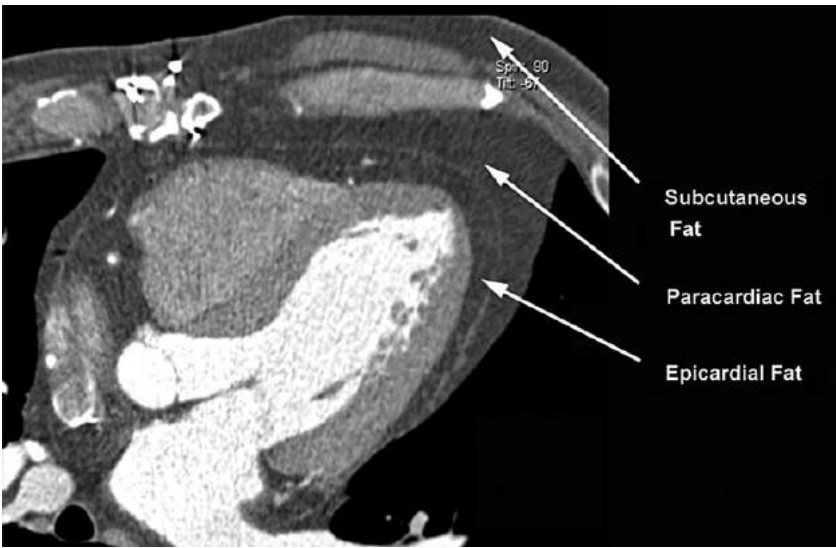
Epicardial fat (often referred to as ‘pericardial fat’), paracardiac fat, and subcutaneous fat in computed tomography. Epicardial fat is correlated with coronary atherosclerosis and the amount of epicardial fat is predictive for future cardiovascular events.
